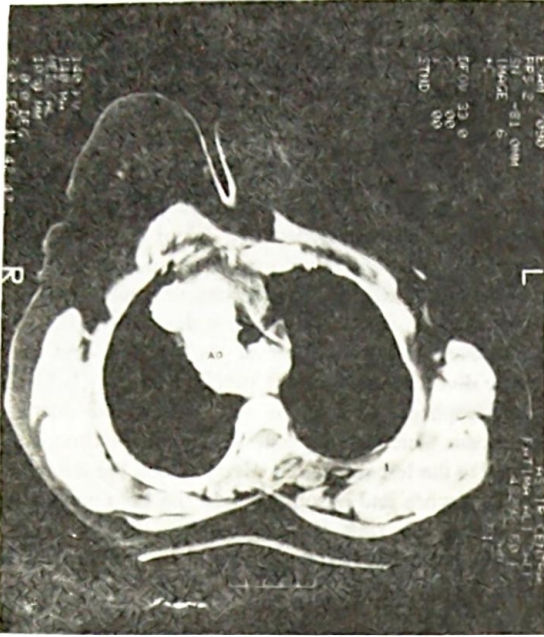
CT Scan on Case 2 showing only Right-sided aortic (AO); no hilar mass or aneurysm.
